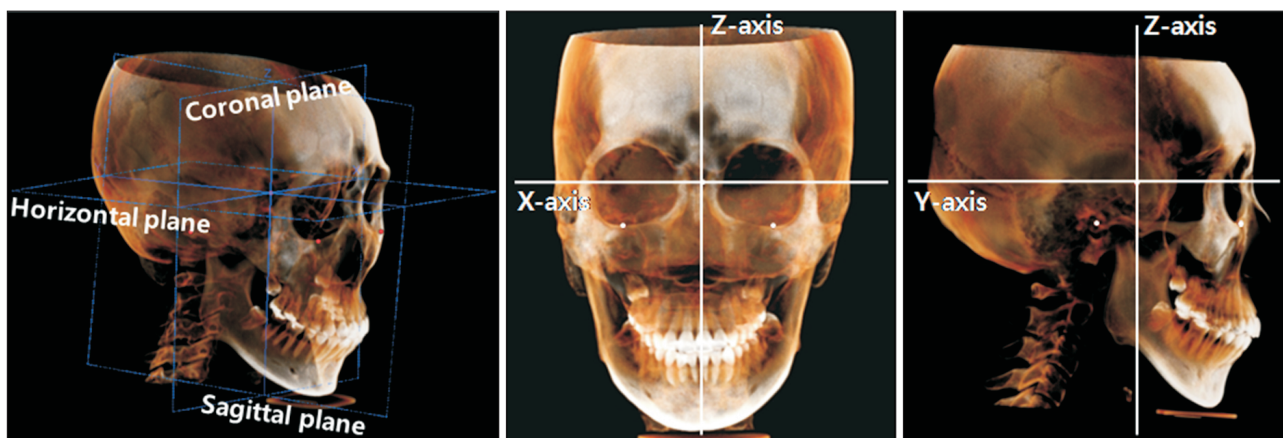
Three-dimensional reconstruction and orientation of the cone-beam computed tomography image with three reference planes and three axes. The origin was set at the sella.
